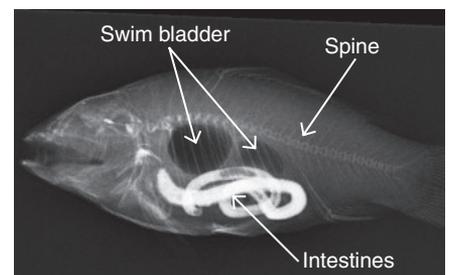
Administration of oral contrast material such as barium sulfate or iohexol can be used to outline the gastrointestinal tract. Right lateral view of a contrast study in a fish. The arrows identify major structures easily identified on fish radiographs: the swim bladder, gastrointestinal tract and spine.
